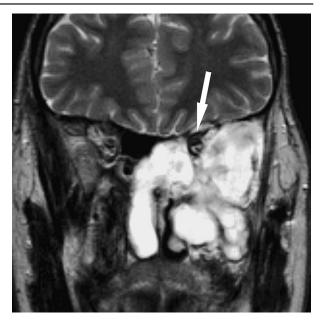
T2-weighted (T2W) coronal view at the level of the orbital apex, demonstrating the CSF-containing cysts (bright signal) not only in the ethmoid and nasal cavity, but medial to the left orbit (white arrow) and (inferiorly) in the pterygomaxillary and retromaxillary space.
